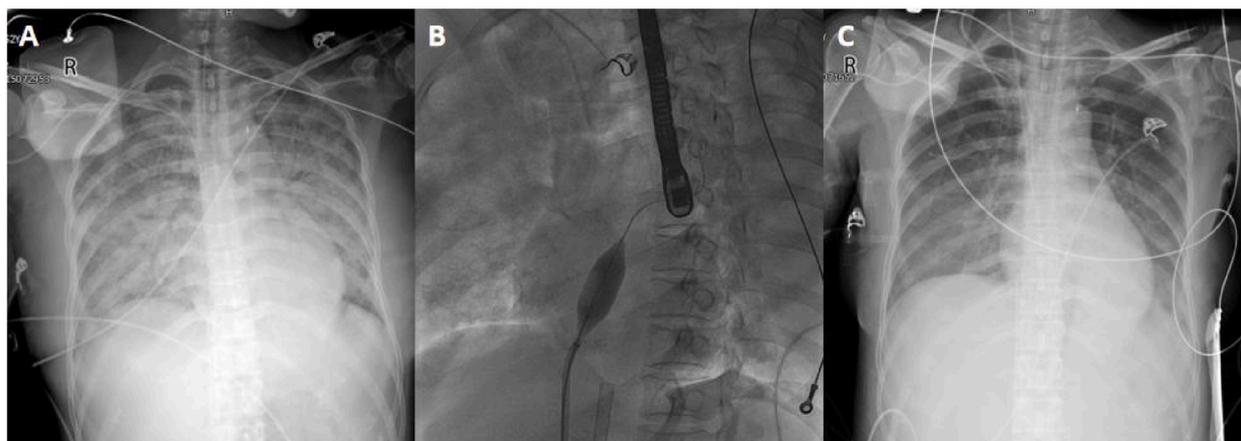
On hospital admission, the chest X-ray showed pulmonary edema (A); The patient underwent percutaneous balloon atrial septostomy (B); The left ventricular distension and pulmonary edema improved after atrial septostomy (C).
